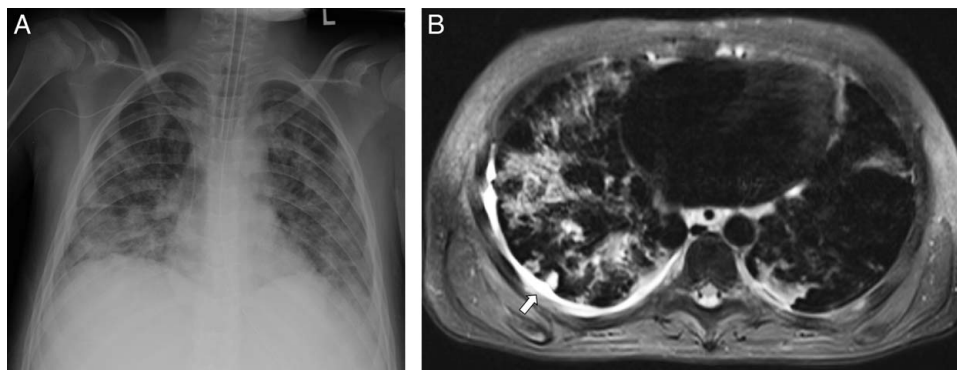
A 13-year-old boy with fever and leukocytosis and bronchopneumonia due to *Streptococcus pneumoniae*. A, Frontal chest radiograph demonstrates bilateral multifocal pulmonary opacities. B, Axial nonenhanced T2-weighted fat suppressed MR image shows bilateral patchy regions of T2 hyperintensity throughout bilateral lungs and a small right pleural effusion (arrow).
